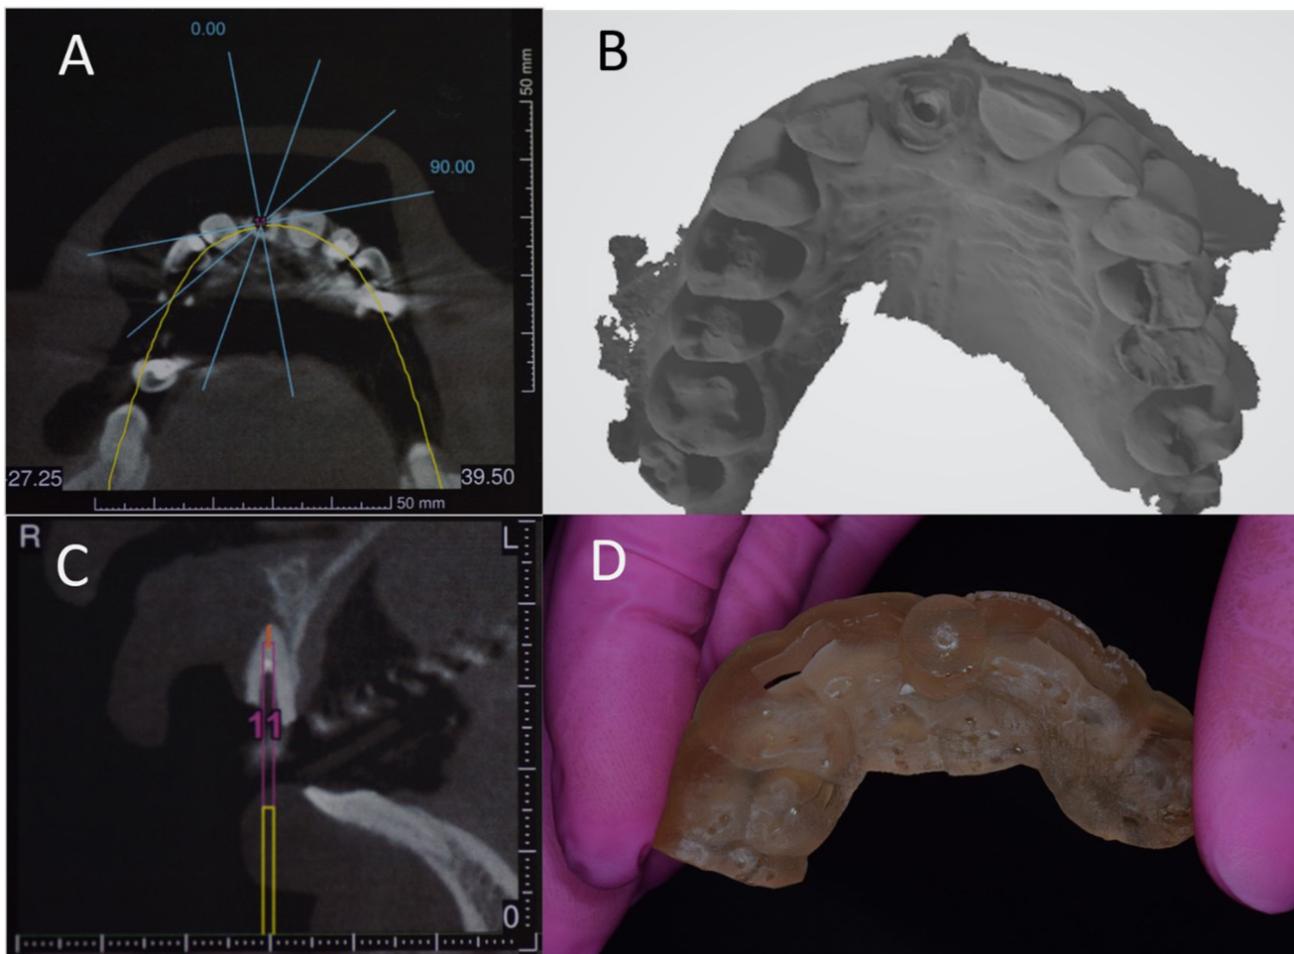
CBCT images and intraoral impression to design the guided endodontic template. (A) and (C) Virtual planning of the guided endodontic template in CBCT images at axial section; (B) intraoral impression; (D) the template after impression.
